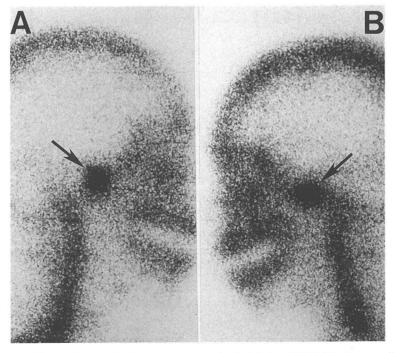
Bone scintigraphy demonstrates uptake in bilateral TMJ (black arrows).
